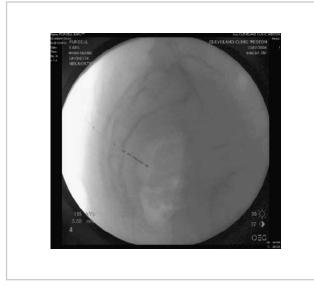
Lateral view of radiograph showing the implanted lead.
